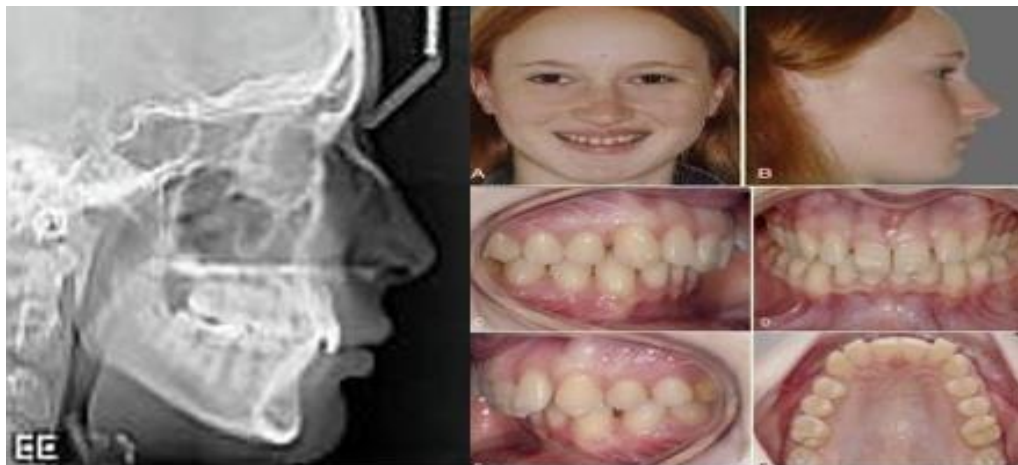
Pretreatment radiograph and photographs (Roberts and Huja, 2016)
